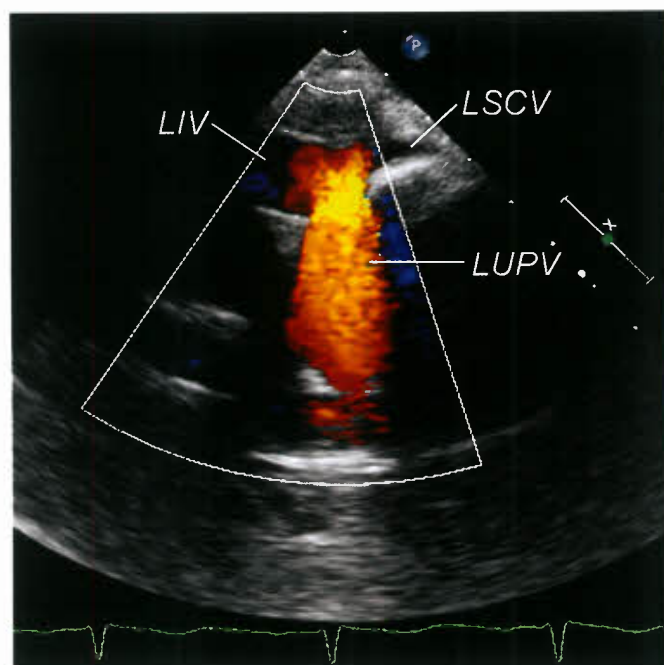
Partially anomalous pulmonary venous connection. Echocardiogram from the high left parasternal window in the transverse plane with color Doppler imaging showing partially anomalous pulmonary venous connection of the left upper pulmonary vein (LPV) to the LIV. Note the prominent jet of red (antegrade) flow into the inferior aspect of the LIV. LSCV, left subclavian vein.
